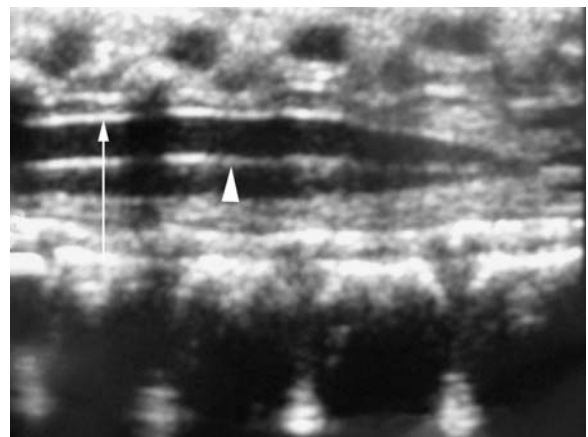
Longitudinal sonographic image of the distal cord. The spinal cord is seen as a hypoechoic tubular structure. The dura forms the outer hyperechoic contours (arrow). Hyperechoic central line represents central spinal canal (arrowhead)
